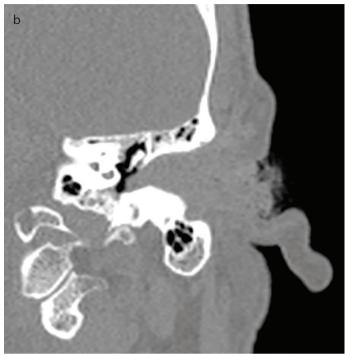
a, b. Non-enhanced preoperative computed tomography scan in the axial (a) and coronal (b) planes showing a soft tissue mass with a complete opacification of the left external auditory canal, without erosion of the bone or abnormalities of the middle or inner ear.
